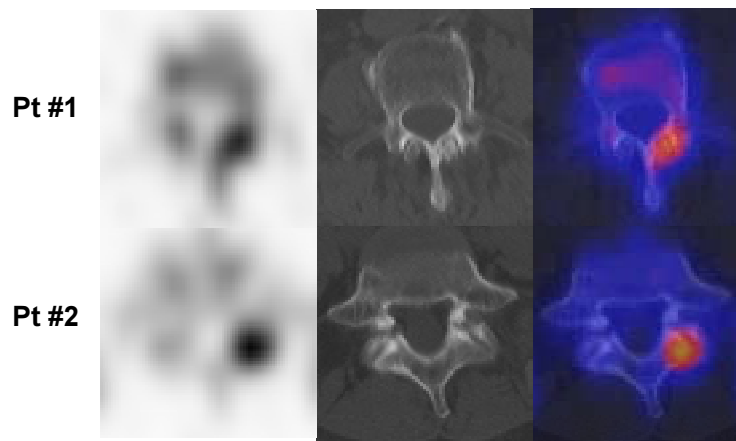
The upper row shows SPECT, CT, and fused images of a lumbar vertebra in a patient with breast cancer (Pt #1). In this patient, increased uptake of ^{99m}Tc -MDP is due to arthrosis of the facet joint. The lower row depicts similar images in another breast cancer patient (Pt #2). Although the SPECT appearance of the lesion is quite similar to that in Pt #1, the CT overlay proves it to be a small osteolysis.
